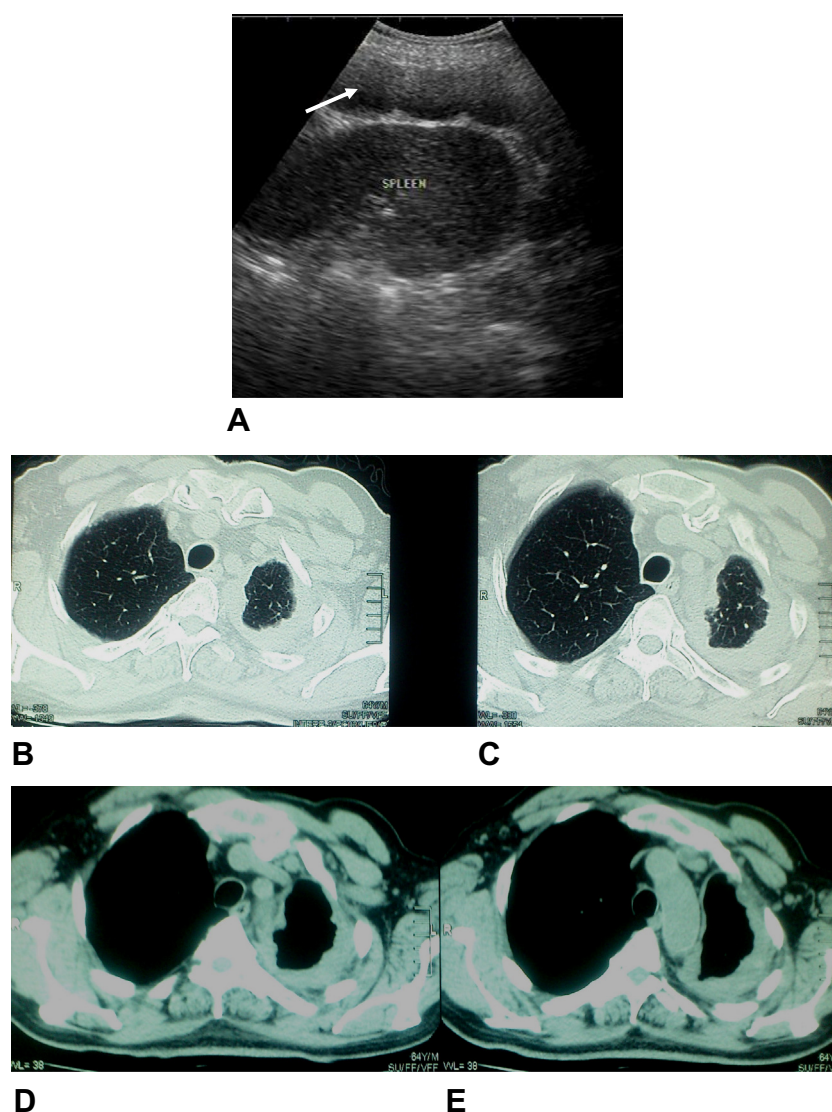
(A) Chest US image in B-mode displays a hypoechoic band of continuous pleural thickening involving the left diaphragmatic pleura (arrowed). (B–E) Postcontrast chest CT images in lung (B and C) and mediastinal (D and E) window settings display lobulated circumferential left pleural thickening which involves the mediastinal and costal pleural surfaces with volume loss of the underlying lung. The patient was pathologically proven to have pleural mesothelioma.
